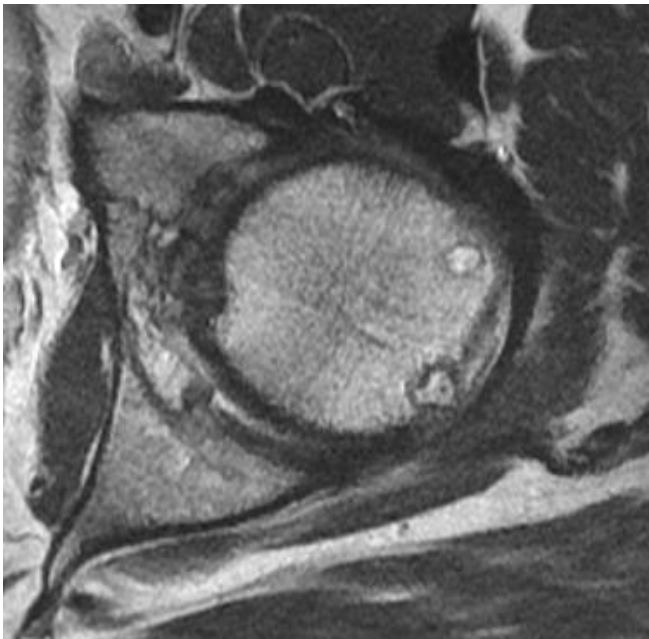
Axial FSE MR image of the left hip shows cystic changes along the lateral aspect of the femoral head. Cysts along the anterolateral aspect of the femoral head-neck junction and subcapital region are also known as synovial herniation pits.
